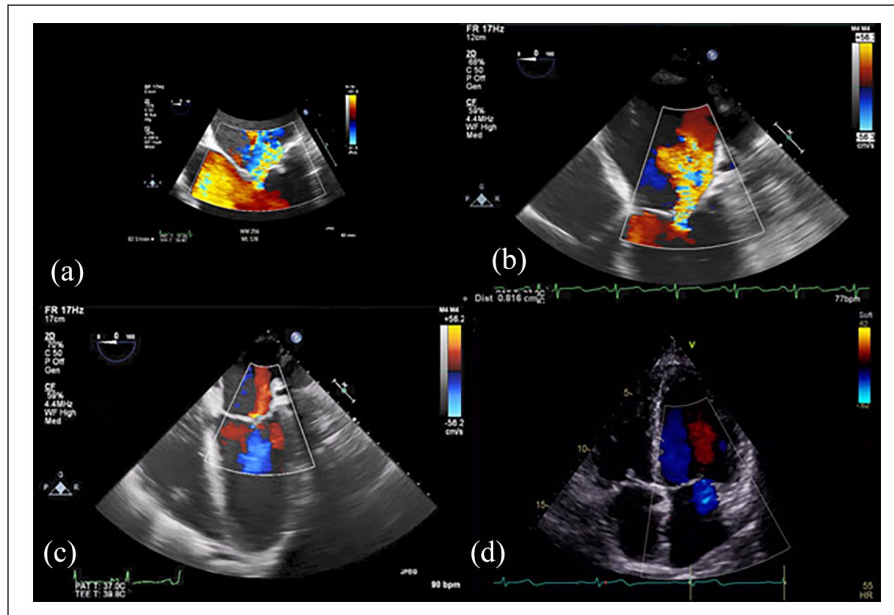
(a) Initial transesophageal echocardiography (TEE) zoomed midesophageal 4-chamber (ME-4CH) view showing moderate mitral regurgitation (MR) (zoomed recording resized to match scale of Panel b). (b) Initial intraoperative TEE vena contracta (VC) measurement of severe MR in ME-4CH view before surgery. (c) Intraoperative TEE after aortic valve replacement (AVR) and cardiopulmonary bypass (CPB). (d) Postoperative transthoracic echocardiography (TTE) apical 4-chamber view with mild MR (4 months after AVR).
